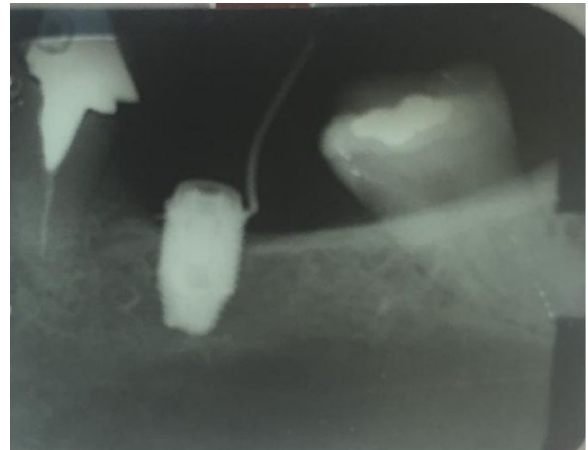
Radiographic aspect of fistulae of Figure 4. HE, 5.0 mm x 10 mm (Exopro S/A, P-I Bra°nemark Philosophy, Bauru, Brazil)
